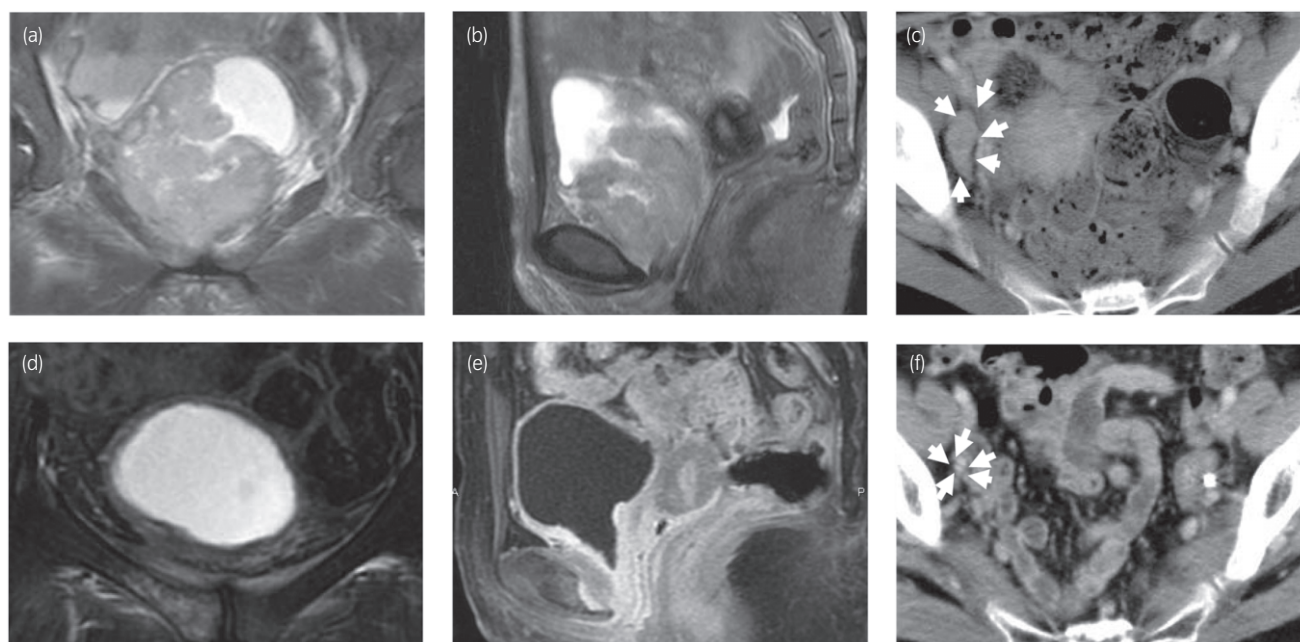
Magnetic resonance imaging (MRI) before (a, b, c) and after (d, e, f) the treatment. The horizontal (a), coronal (b) and sagittal (c) MRI slices reveal that bulky tumors occupy more than half of the bladder cavity, and that the tumors invade the abdominal wall, indicating stage T4. In contrast, all imaging studies (d, horizontal; e, coronal; and e, sagittal slices) confirm a complete disappearance of the tumors, and that the mucosa and muscle layer are intact at 10 weeks after completion of the therapy.
